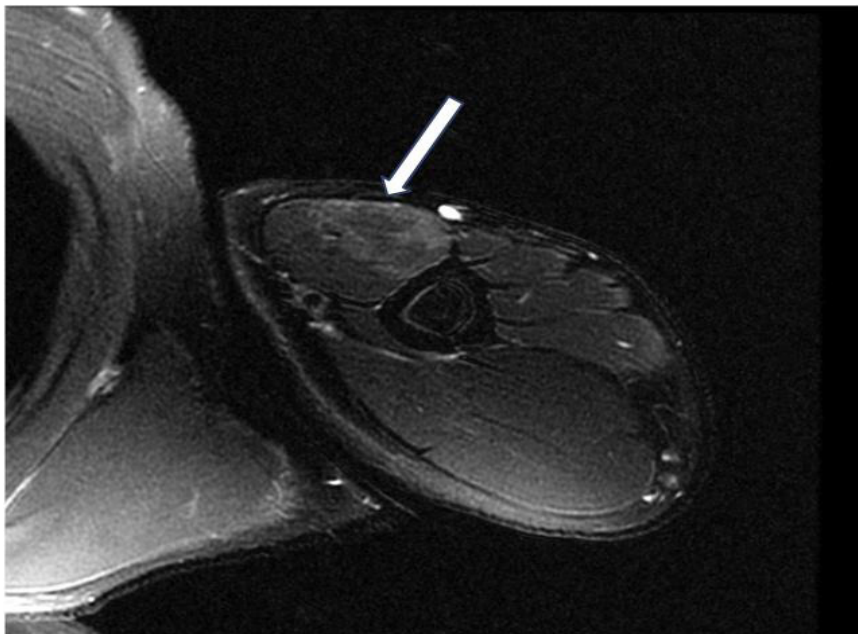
Axial sections of T2-weighted magnetic resonance images of the left humerus. Diffuse intermediate signal intensity is apparent in the short and long heads of the biceps brachii muscles
